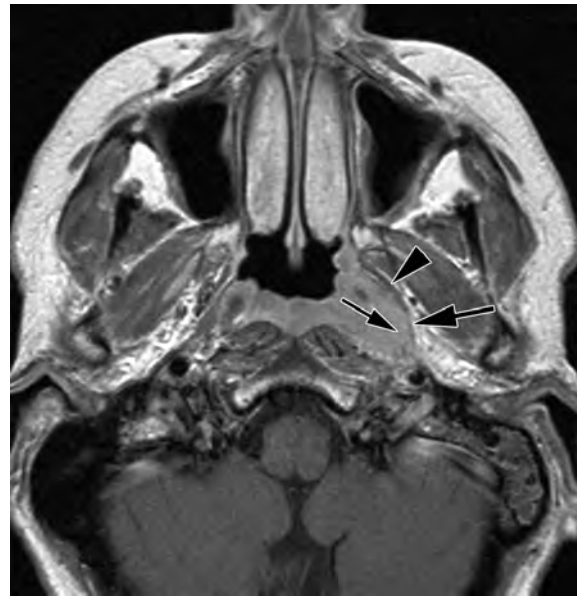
Axial gadolinium-enhanced T1-weighted spin echo image in a patient suffering nasopharyngeal carcinoma. The tumor extends posterolaterally (*small arrow*) in the retrostyloid compartment of the PPS, and remains sharply demarcated from the prestyloid compartment by the tensor veli palatini muscle (*arrowhead*) and tensor-vascular-styloid fascia (*large arrow*), although the fat plane is somewhat pushed laterally
